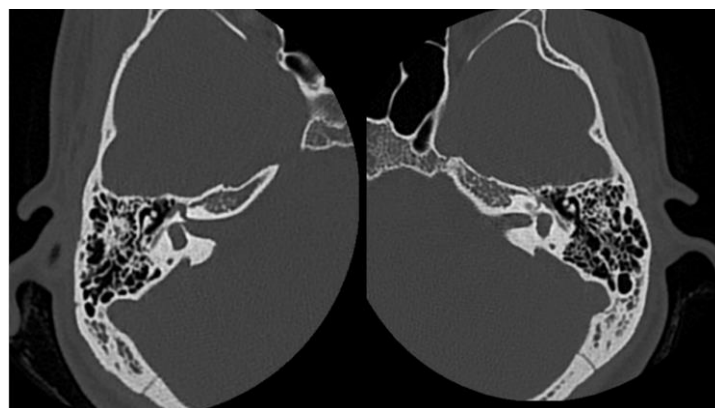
Axial HRCT image demonstrating enlarged vestibule associated with cochleovestibular malformation
